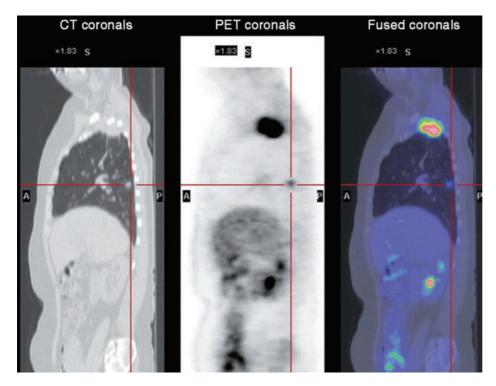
Coronal CT, PET and fused scan images of upper thoracic region in July 2005, demonstrating intense uptake in the right lung apex and apical segment of right lower lung lobe
